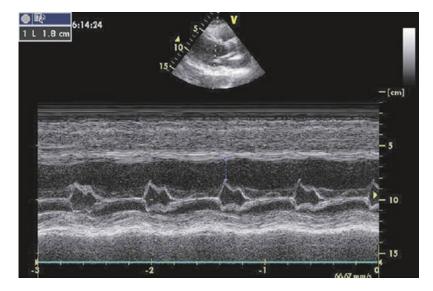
Parasternal long-axis (TTE) M-mode image at the level of mitral valve: increased distance between the septum and the maximum diastolic excursion of the mitral valve. (From Sarti with permission)
